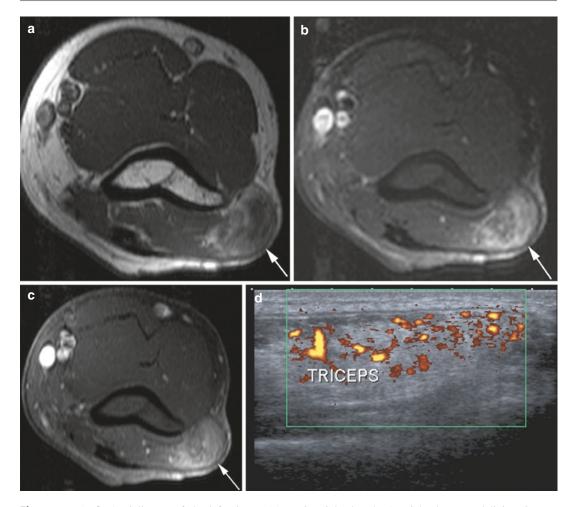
(a–d) Angiolipoma of the left triceps. (a) Axial SE T1-weighted MR image. (b) Axial fat-suppressed SE T2-weighted MR image. (c) Axial fat-suppressed SE T1-weighted MR image post gadolinium. (d) Ultrasound. The mass (*arrow*) within the lateral head of triceps shows some fat signal on MR images with linear areas of low SI on T1-weighted images which have increased SI on
